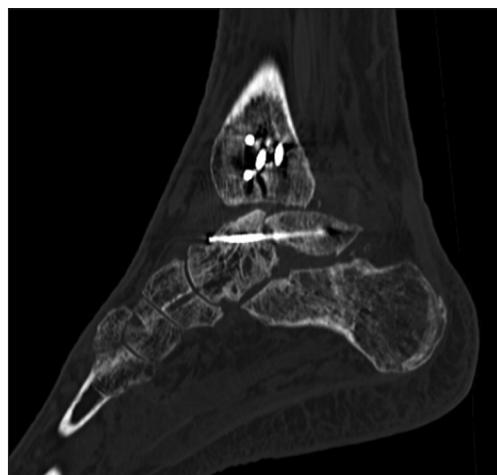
This sagittal computed tomography view of the ankle demonstrates superior collapse of the talar dome superior to the screw fixation with a step-off of the articular surface of the talus
